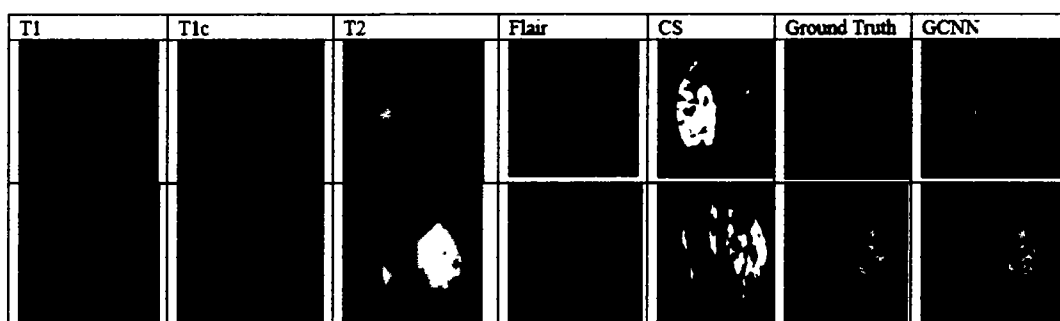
predated MRI model
